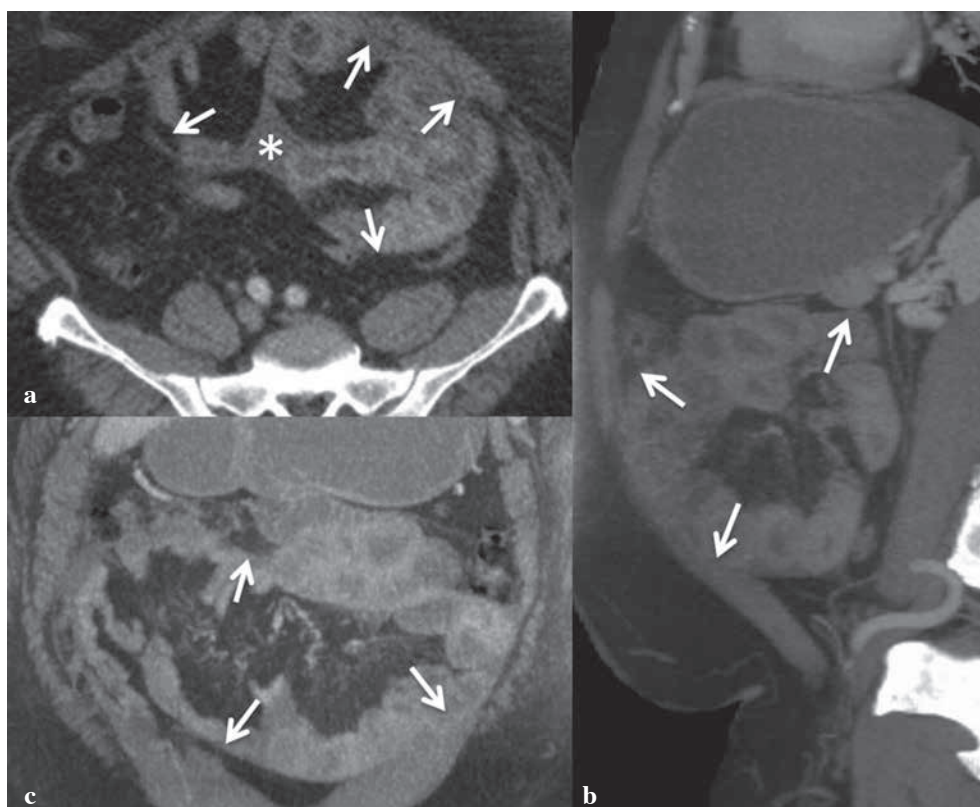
A fifty-five year old male was admitted to general surgery clinic with complaints of colicky abdominal pain, increased bowel sounds and intestinal motility, nausea, and vomiting. Axial (a), sagittal (b) and coronal (c) MIP reformatted intravenous contrast enhanced CT images showed that small bowel segments stuck in the fibrous sac (arrows), which was hardly seen. Free intraabdominal fluid was best seen on the axial image (asterisks).
